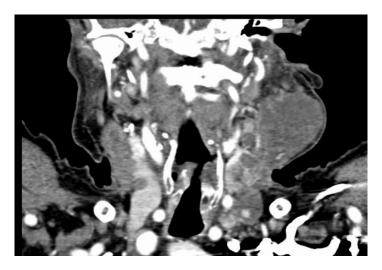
Contrast CT scan of case 2- revealing partial compression of right internal jugular vein and completely obliterated left internal jugular vein by a massively enlarged thyroid carcinoma metastatic lymph node.
